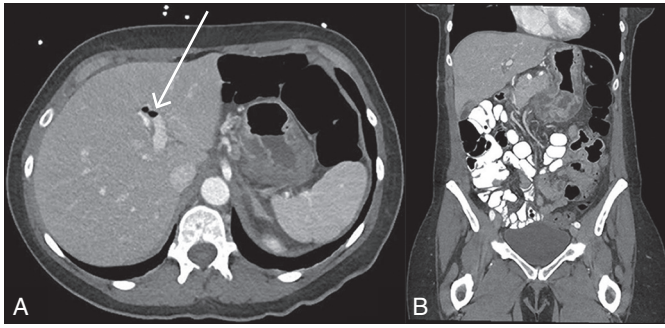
Computed tomography imaging of abdomen and pelvis (A) axial and (B) coronal image showing gastric wall thickening and mucosal hyperenhancement with associated portal venous gas and gastric pneumatosis.
